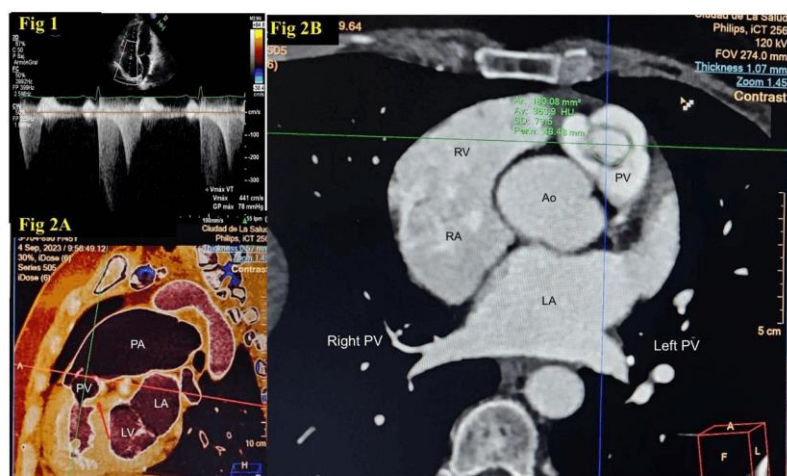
Transthoracic echocardiogram showing double gradient at the tricuspid valve level. Fig. 2. Cardiac TC, 2A Sagittal plane-3D reconstruction. 2B axial plane.
